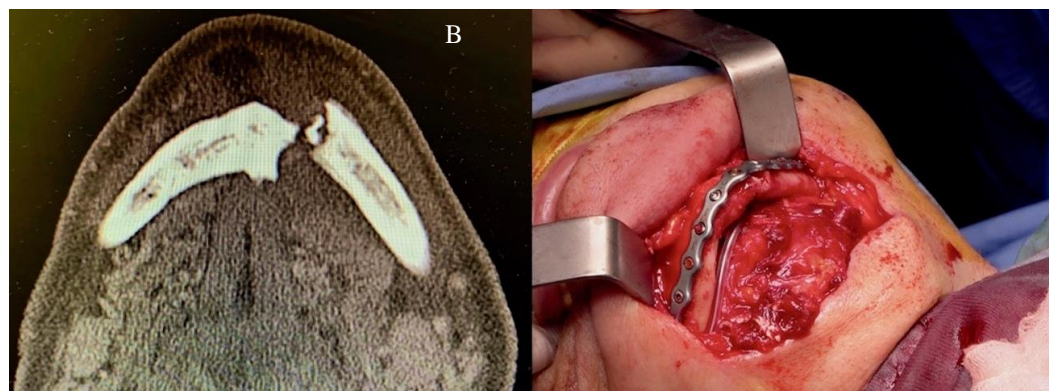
(A) Evidence of line fracture on CBCT of case 3. (B) Bone fixation after curettage and reduction of the fracture in case 3.
